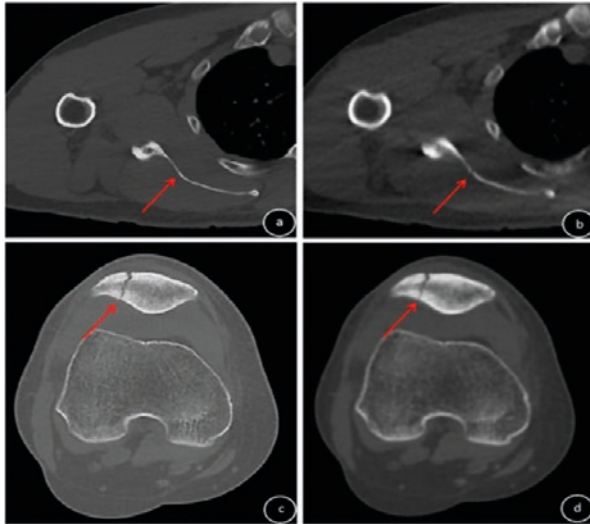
Comparison of quality (a, c) standard CT and ULDCCT (b, d) protocols in the diagnosis of non-displaced fractures (a, b) of the shoulder, (c, d) knee. (Source: <https://pubmed.ncbi.nlm.nih.gov/36882617/>)
